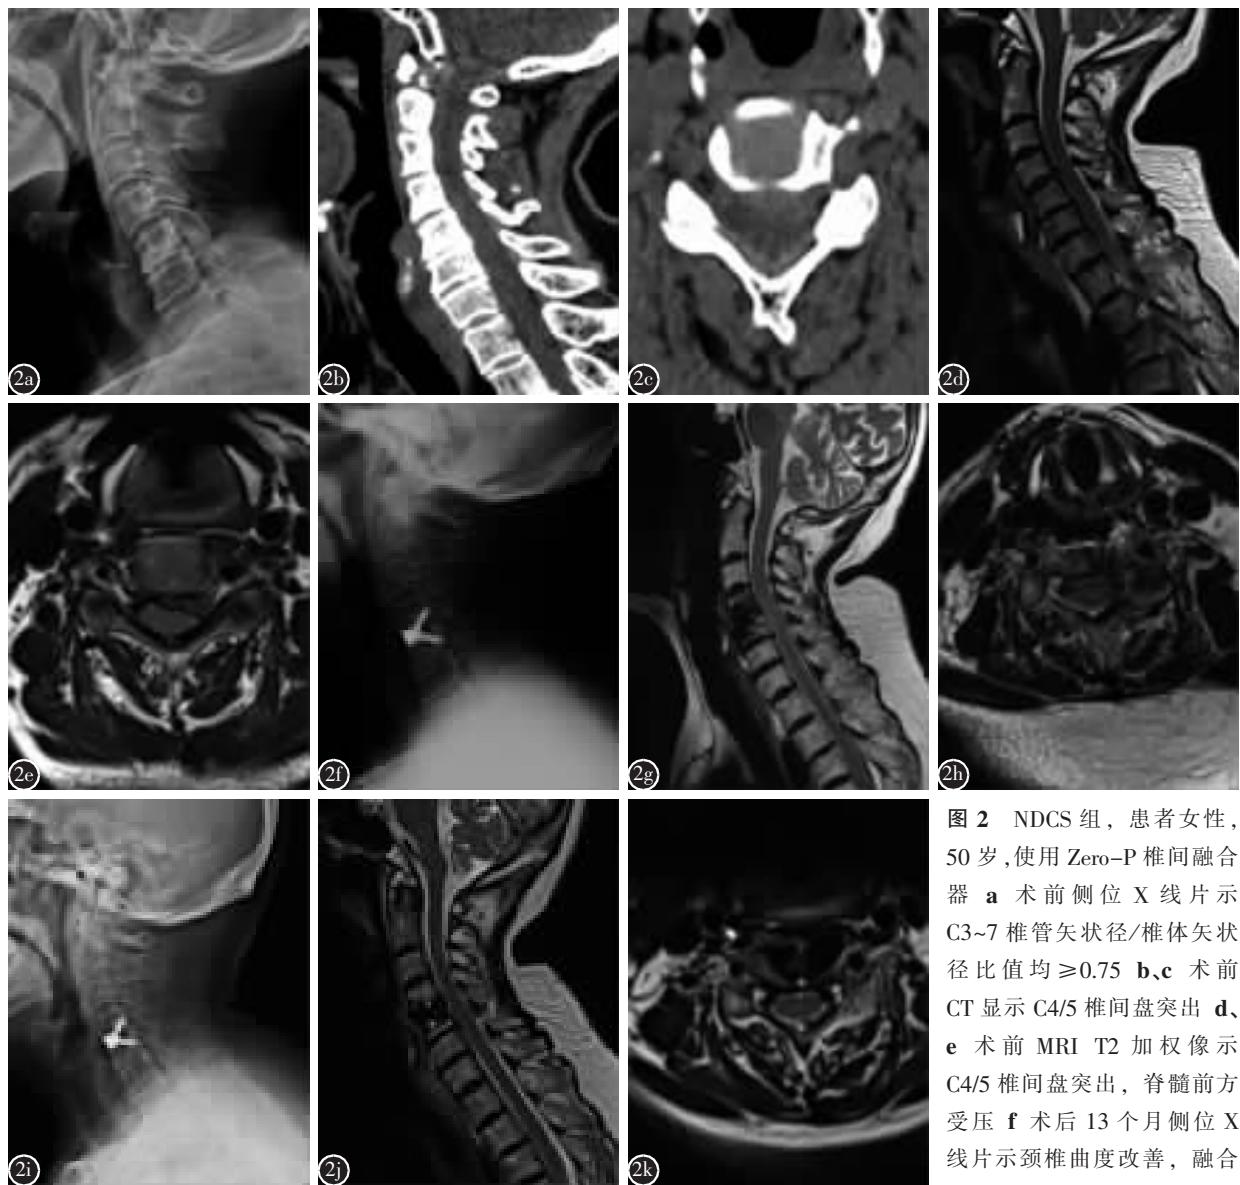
NDCS 组, 患者女性, 50岁, 使用 Zero-P 椎间融合器 a 术前侧位 X 线片示 C3~7 椎管矢状径/椎体矢状径比值均 ≥ 0.75 b、c 术前 CT 显示 C4/5 椎间盘突出 d、e 术前 MRI T2 加权像示 C4/5 椎间盘突出, 脊髓前方受压 f 术后 13 个月侧位 X 线片示颈椎曲度改善, 融合器位置良好 g、h 术后 13 个
